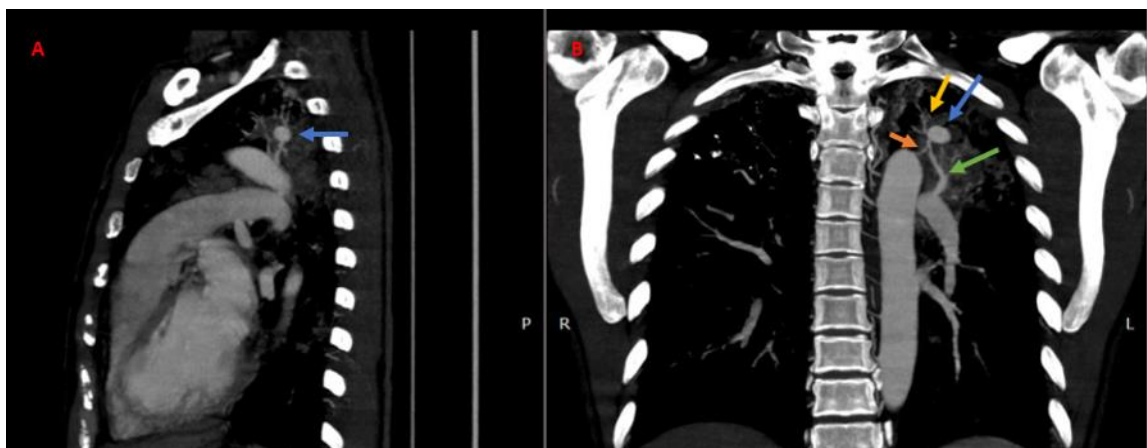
Chest CT Angiography Depicts Rasmussen's Aneurysm.
